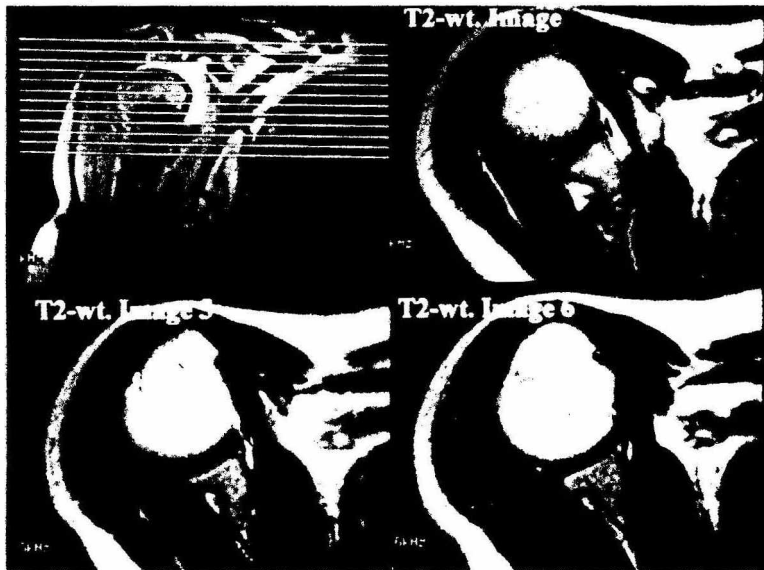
T2-weighted axial image suggested suspicious tear of middle glenohumeral ligament at 2 to 3 O'clock position of the glenoid(Image 4, 5). There was no discernible changes under this level of the glenoid labrum(Image 6).
